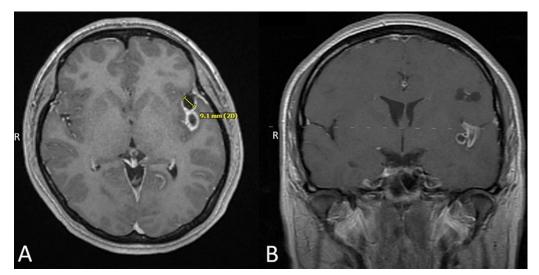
MRI Brain image demonstrating subarachnoid Neurocytsicercosis 98 (A – axial; B – coronal Post Contrast images) Complex Cysticerci cysts in the subarachnoid space of the left Sylvian fissure between the temporal and parietal lobes.
